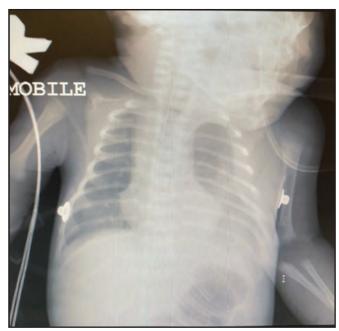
A chest x-ray of the neonate given oxygen supplementation revealed left lower zone opacity/consolidation
